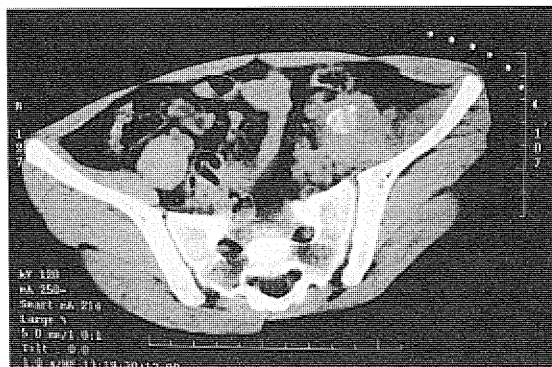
Abdominal plain CT. A soft tissue mass accompanied by calcification in the left iliopsoas muscle
